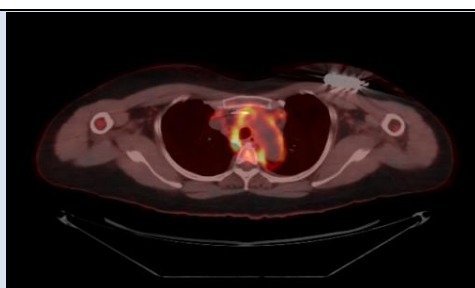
FDG PET/CT scan image, axial view at the aortic arch level shows FDG hypermetabolism along the wall of the aortic arch, likely representing sarcoid vasculitis.
